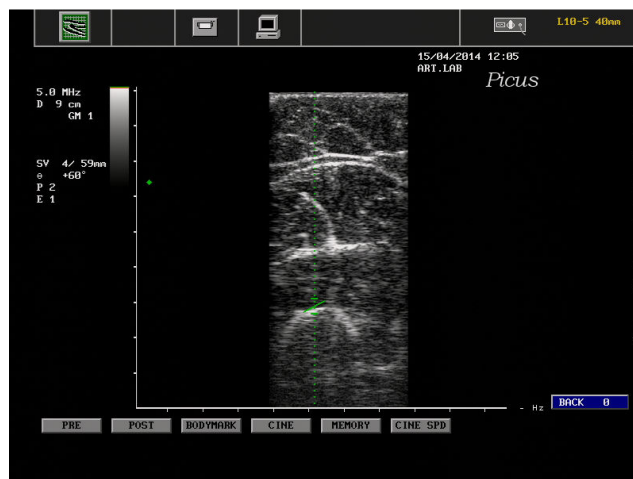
Ultrasound image of tissue thickness
